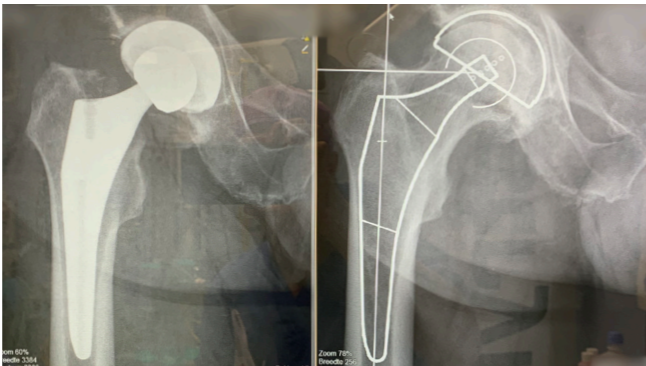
Templating: pre- & postoperative x-ray
